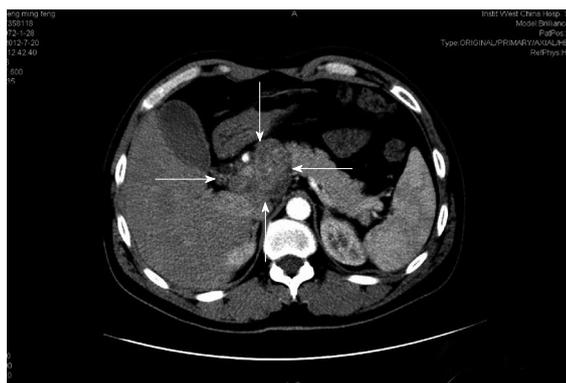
Computed tomography of a pancreatic tuberculosis lesion. Computed tomography revealed a necrotic and calcified cystic lesion (white arrows) with well-defined margins in the head of the pancreas; the lesion mimicked pancreatic head carcinoma.
